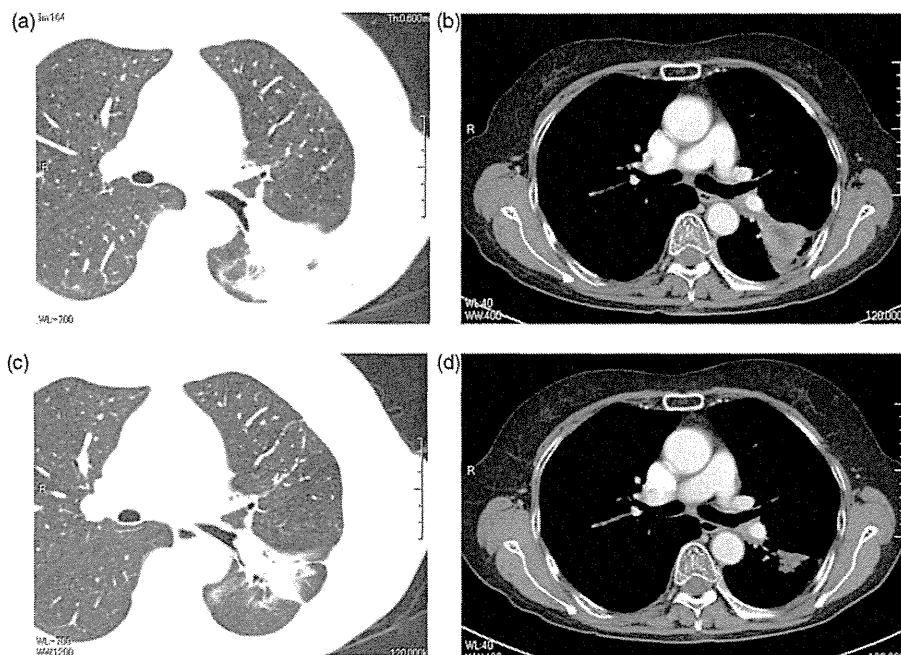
Chest computed tomography showing a 50-mm tumor in the left lower lobe before treatment with gefitinib (a) and (b). The shrunken tumor, with a size reduction of 40% after treatment with gefitinib (c) and (d).
